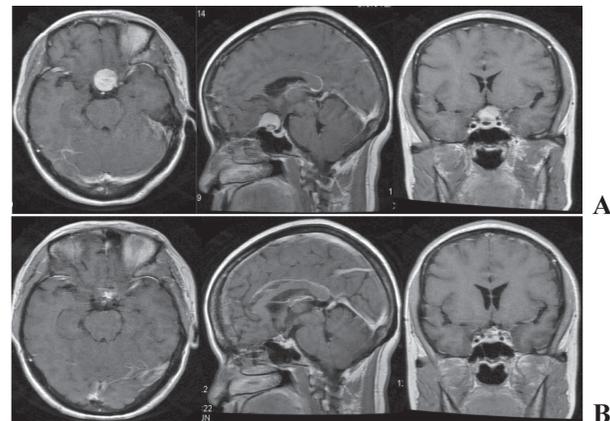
MRI of 42-year female presented with headache and decrease in vision. (A) Preoperative MRI (B) Post-operative MRI showing complete resection via supraorbital keyhole approach through eyebrow incision.
